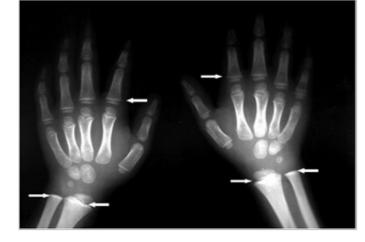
Long Bone Radiograph of Hands – "lead lines" shown as increased density on the metaphysis (growth plate) of the proximal segments of phalanges and distal segments of ulna and radius in a 5-year-old male with radiological growth retardation and BLL of 37.7 μg/dL (Photo courtesy of Dr. Celsa López, Clinical Epidemiologic Research Unit, IMSS, Torreón, México).
